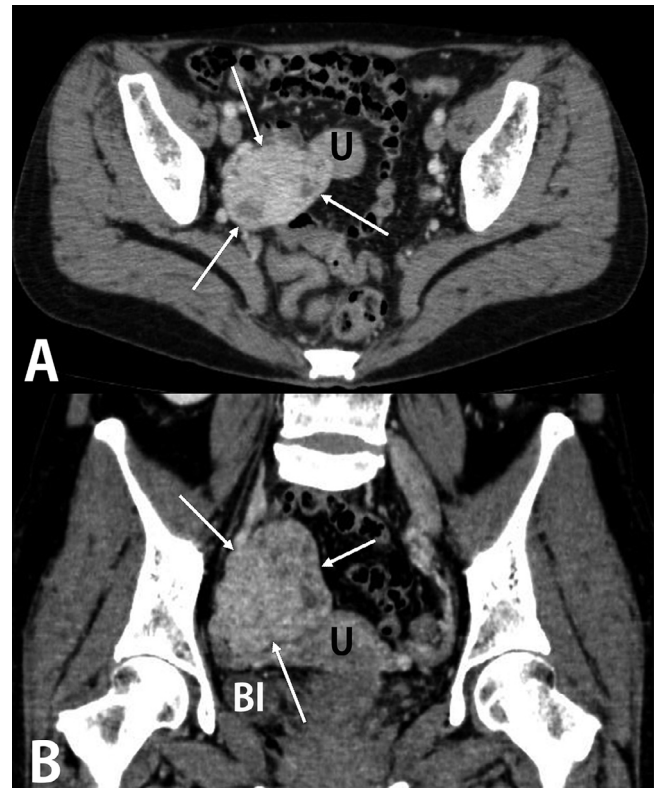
Contrast-enhanced (A) axial and (B) reformatted coronal abdominal computed tomography showed a solid tumor (arrow) with non-homogeneous enhancement adjacent to the uterine fundus (U). No bridging vessels were observed between the tumor and the uterus.
